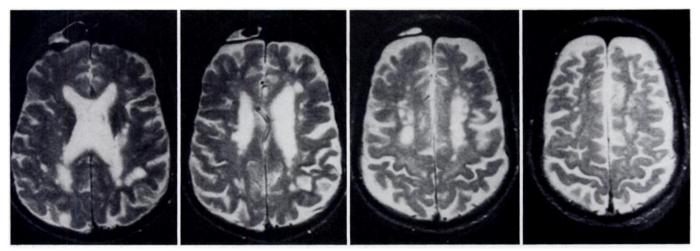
MR images show microangiopathic leukoencephalopathy. T2-weighted MR images (SE 2,500/80) demonstrate multiple, at times confluent, areas of increased SI throughout the deep white matter with sparing of the arcuate fibers in the brain of a 73-year-old patient with dementia. Although the marked prominence of the cortical sulci may be related to white matter destruction, the dementia and atrophy in this case could also be due to a primary degenerative dementia (Alzheimer disease) with arteriolar/hypoperfusion abnormalities that was suspected clinically. This case highlights the complex problems of determining a precise cause for a signal hyperintensity (i.e., infarction vs. myelin pallor vs. gliosis vs. atrophic perivascular demyelination) and distinguishing a vascular versus a degenerative cause for dementia.
